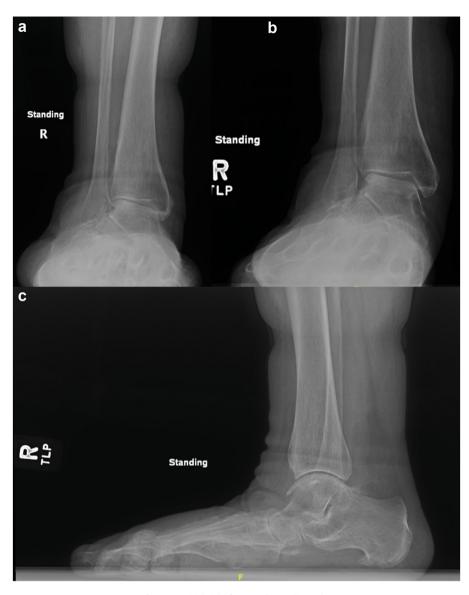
Initial right foot standing radiographs.
